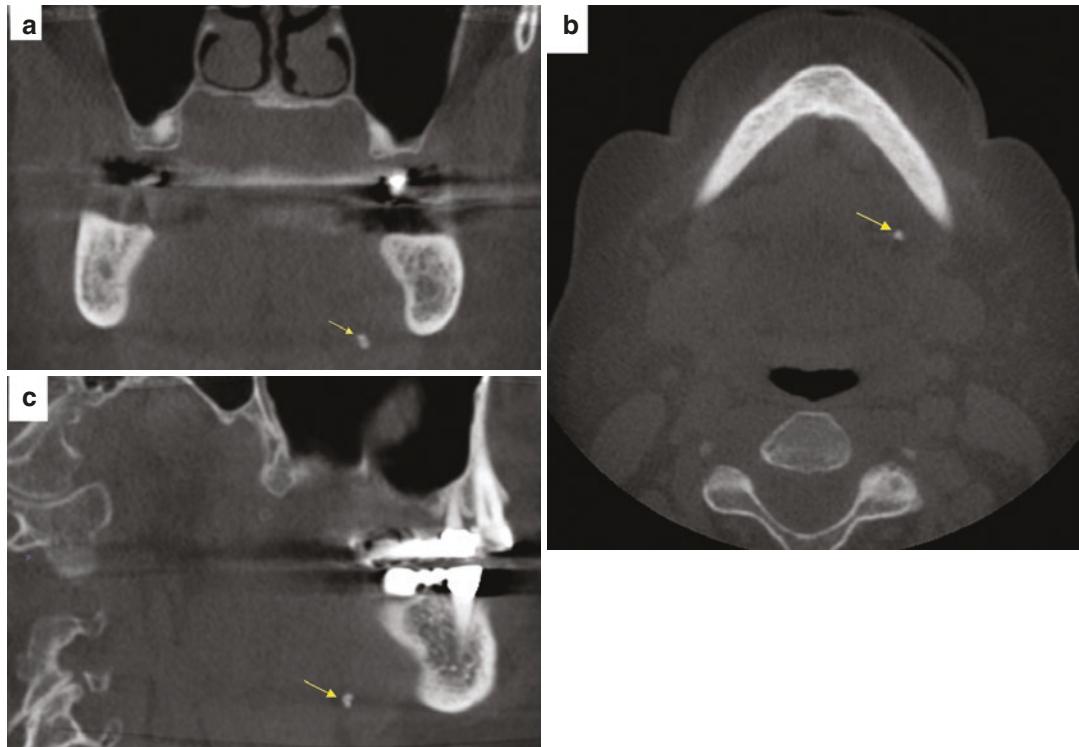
CBCT coronal (a), axial (b), and sagittal (c) images show sialoliths (yellow arrows). Courtesy: Dr. Hui Liang
